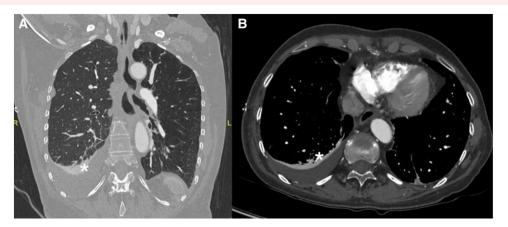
Thoracic-abdominopelvic computer tomography. (A) coronal section, (B) axial section; showing sub-pleural intra-parenchymal haematoma in the right lower lobe in relation to the surgical suture. *marking haematoma. Computer tomography (CT).
